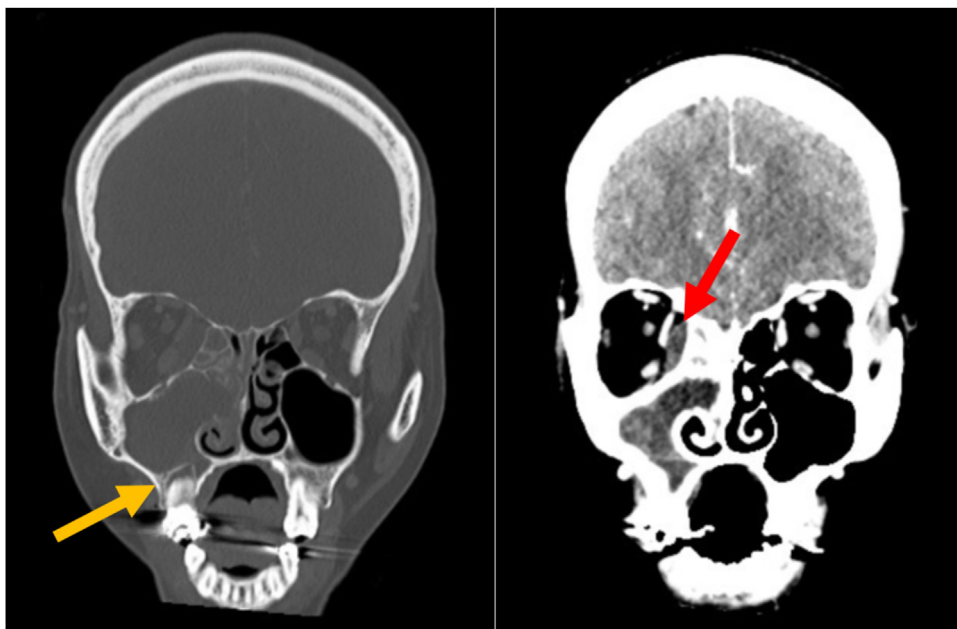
CT scan on day 1, coronal view. Note the right-sided maxillary and ethmoidal sinusitis and apical translucency surrounding the first upper molar (orange arrow). The medial surface of the right orbit appears clouded, suggesting intraorbital infection spread (red arrow).
